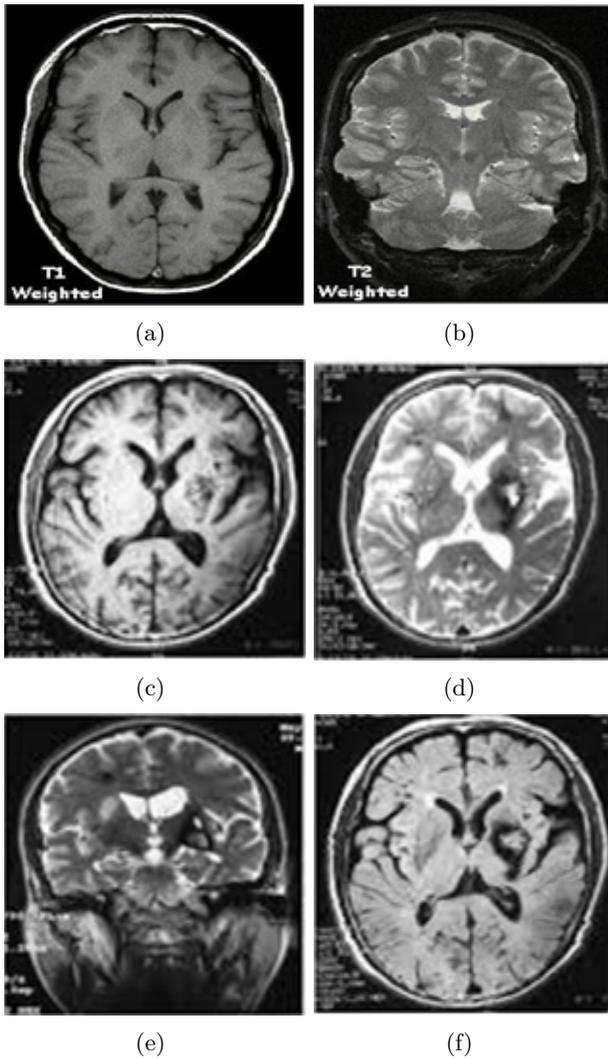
T1 weighted MRI scans (a, c, e), and T2 weighted MRI scans (b, d, f)
